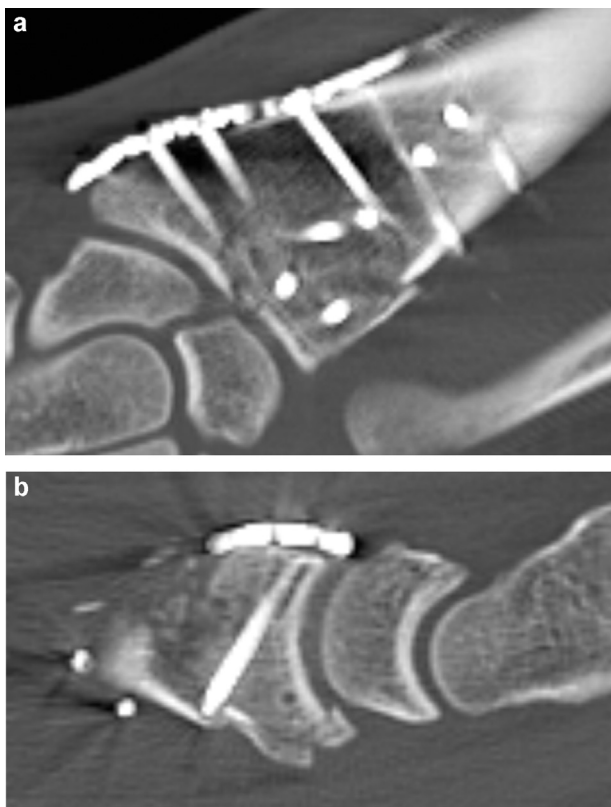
a: postoperative control CT scan. Coronal slices (a). Reconstruction based on sagittal slices (b). The initial dorsal articular impaction has been corrected.
